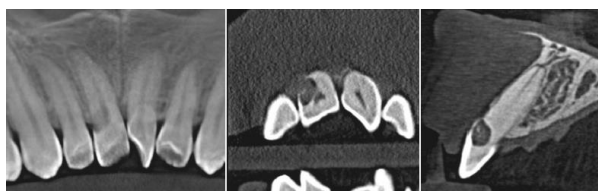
CBCT showing three dimensional extent of the lesion.
